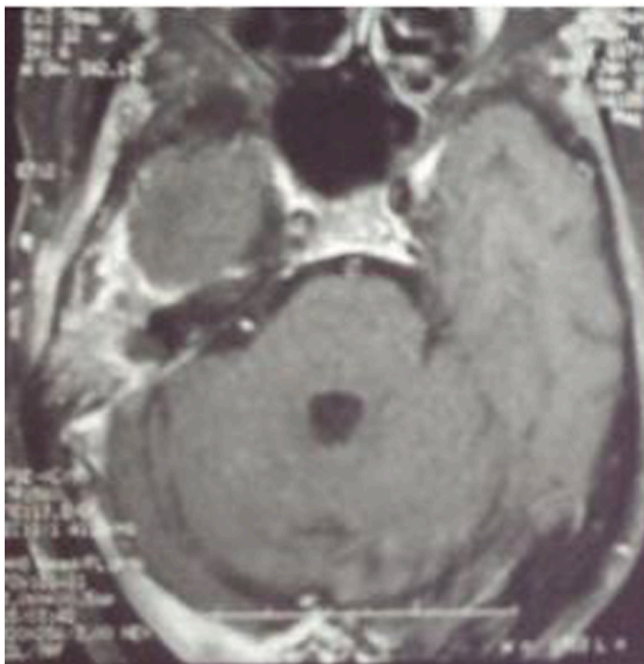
(MRI) demonstrated a heterogeneous enhancing process at the level of the temporal bone.
